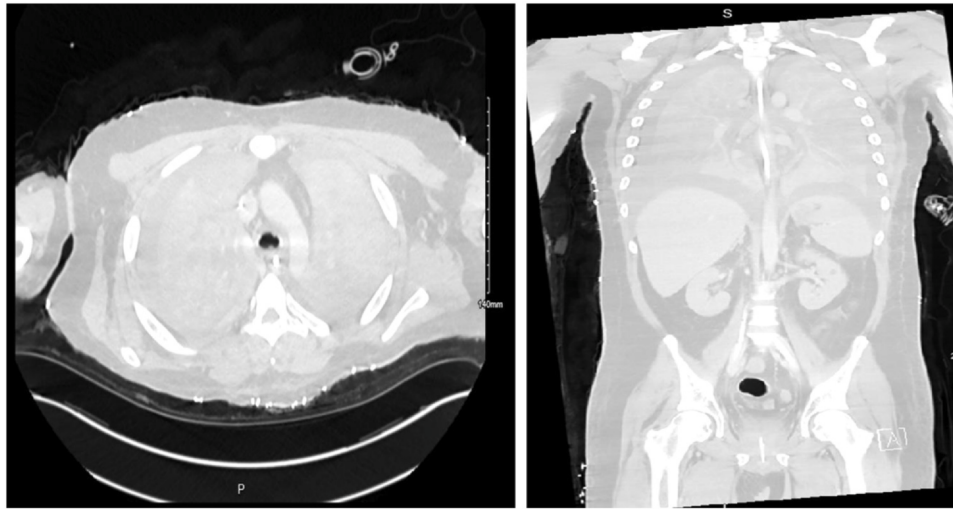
Contrast-enhanced computed tomography (CT) of the thorax obtained on day 21 of admission while the patient was supported on veno-venous extracorporeal membrane oxygenation (VV-ECMO). Axial (left) and coronal (right) views demonstrate complete bilateral pulmonary opacification with moderate pleural effusions. There is absence of aeration of the bronchial tree beyond the main bronchi at the level of the hila bilaterally, findings supported by bronchoscopy which showed extensive sloughing of the mucosa and complete airway destruction.
